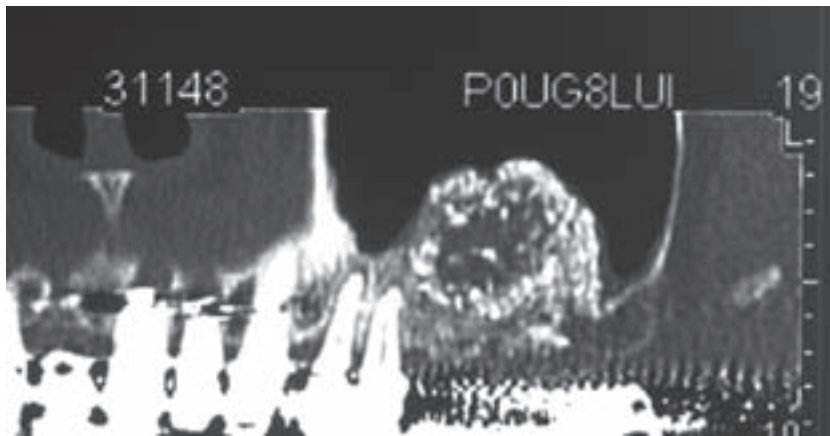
Panoramic CT view of an infected sinus graft showing "black hole".
